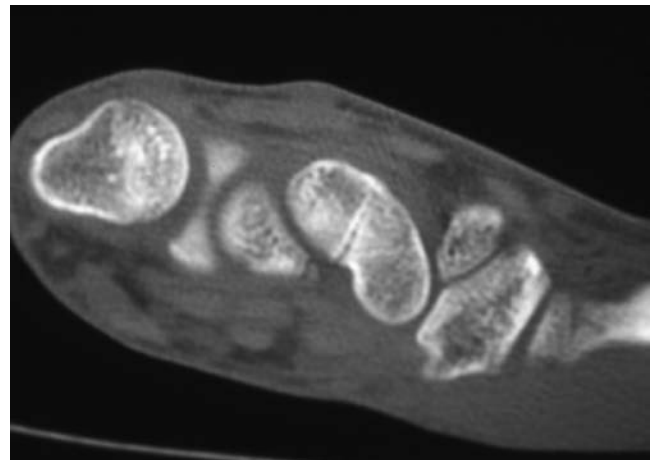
An MRI scan of a minimally displaced healing scaphoid fracture not seen on radiograph.
